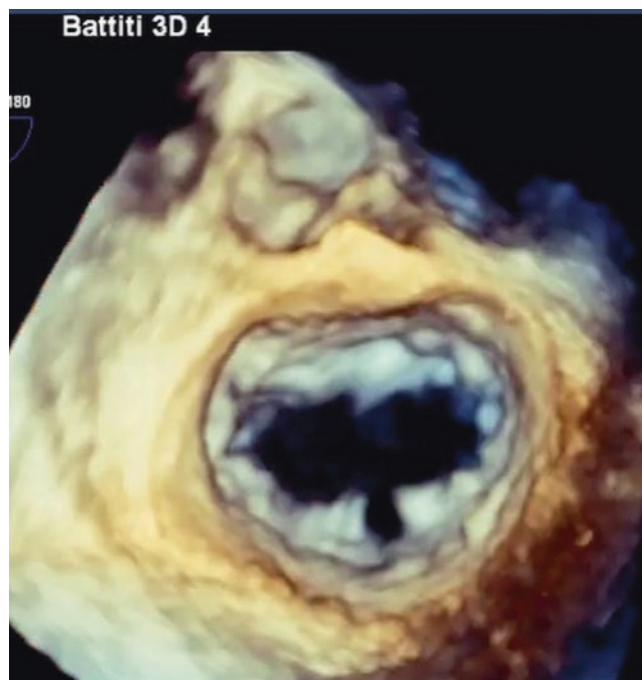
Cleft of the anterior leaflet of the mitral valve. Transthoracic 3DE visualization of the mitral valve from the left ventricular (a, Video 8.3a Left) and left atrial (b, Video 8.3b Right) perspectives showing a cleft (yellow arrow) of the anterior mitral leaflet (AML) in a patient
